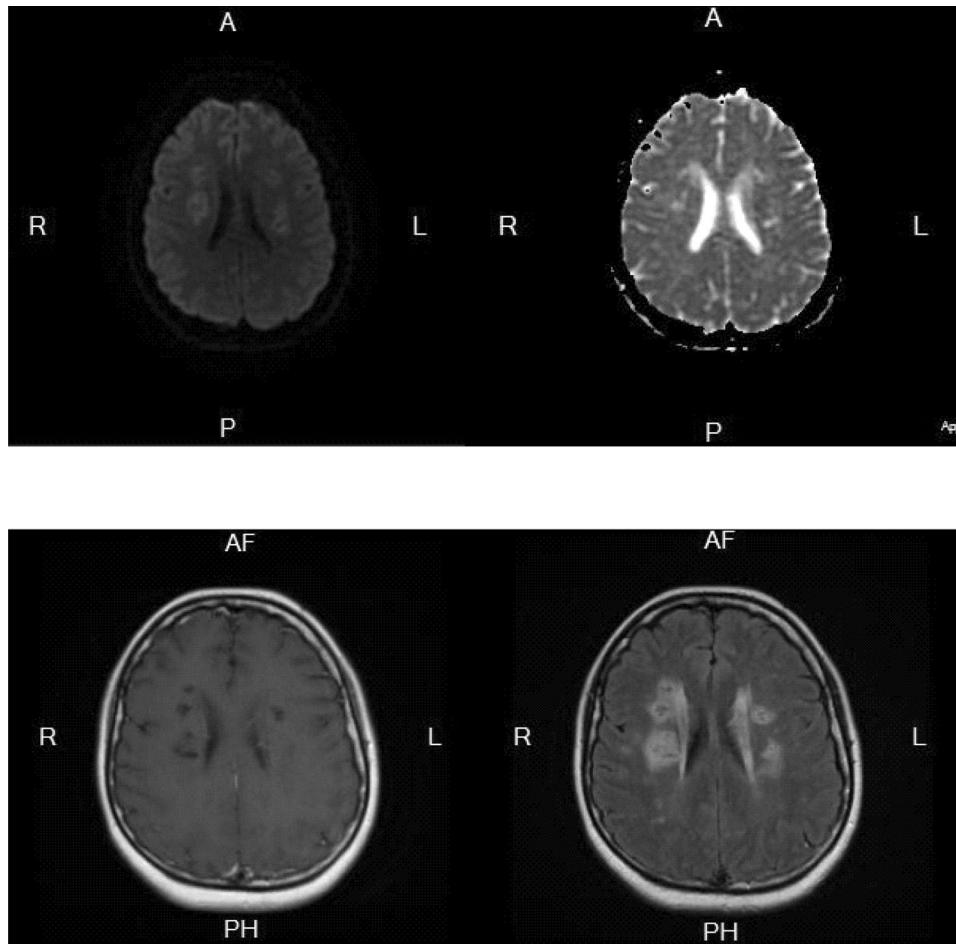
(Top) MRI brain (Top, Left)—subcortical diffusion-weighted imaging (DWI), and (Top, Right) apparent diffusion coefficient (ADC) map changes. (Below) MRI brain—subcortical and temporal T2 FLAIR changes
